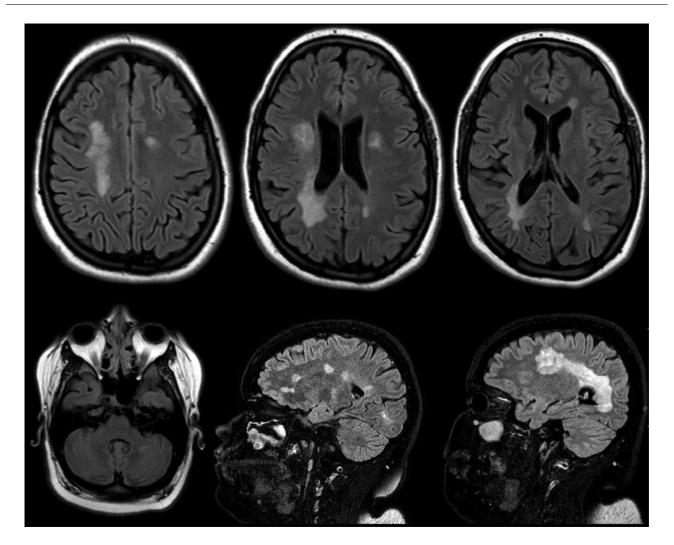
Third MRI (taken 4 months after the second MRI). Axial T2/FLAIR sequences showing improvement of the lesions in frontal and parietal lobes (a–c), pons and cerebellum (d), and absence of contrast-enhancing lesions. Residual hyperintense periventricular lesions on sagittal T2/FLAIR, maintaining Dawson fingers aspect (e) and still a wide extension on frontal, parietal and occipital lobes (f).
